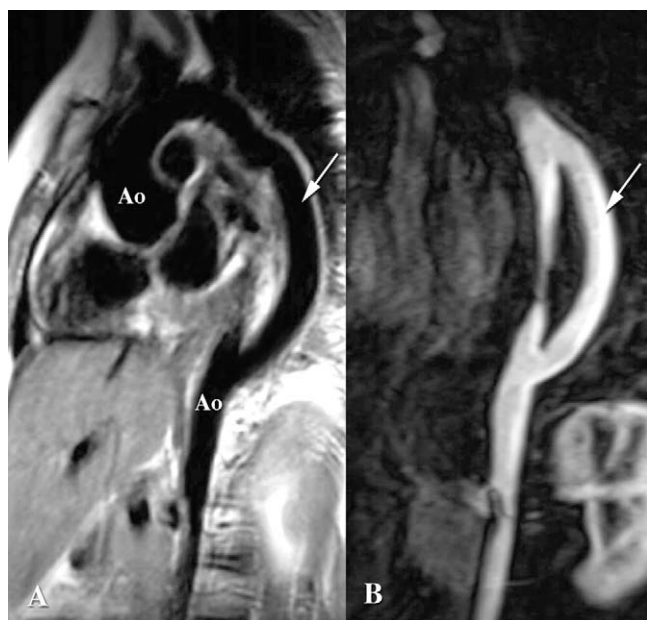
Magnetic resonance imaging (A) and magnetic resonance imaging-angiography (B; patient 6) showing a patent polytetrafluoroethylene bypass graft from the thoracic to abdominal aorta (Ao) at 2 postoperative years.
